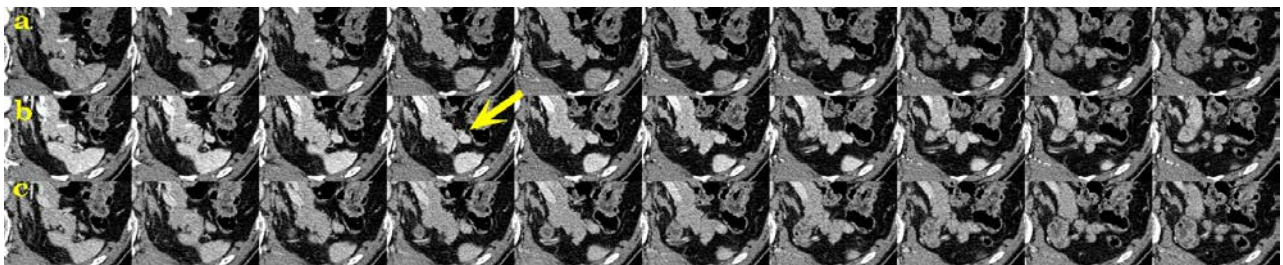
Axial CT scan of patient 3 (slice thickness: 1 mm), at 25 seconds (a), 45 seconds (b), and 80 seconds (c) after the administration of contrast agent, respectively. In the series at 45-seconds a 10 mm well-enhanced tumor is recognized more clearly than in other series, and this tumor is hard to discern in the series at 80-seconds.
